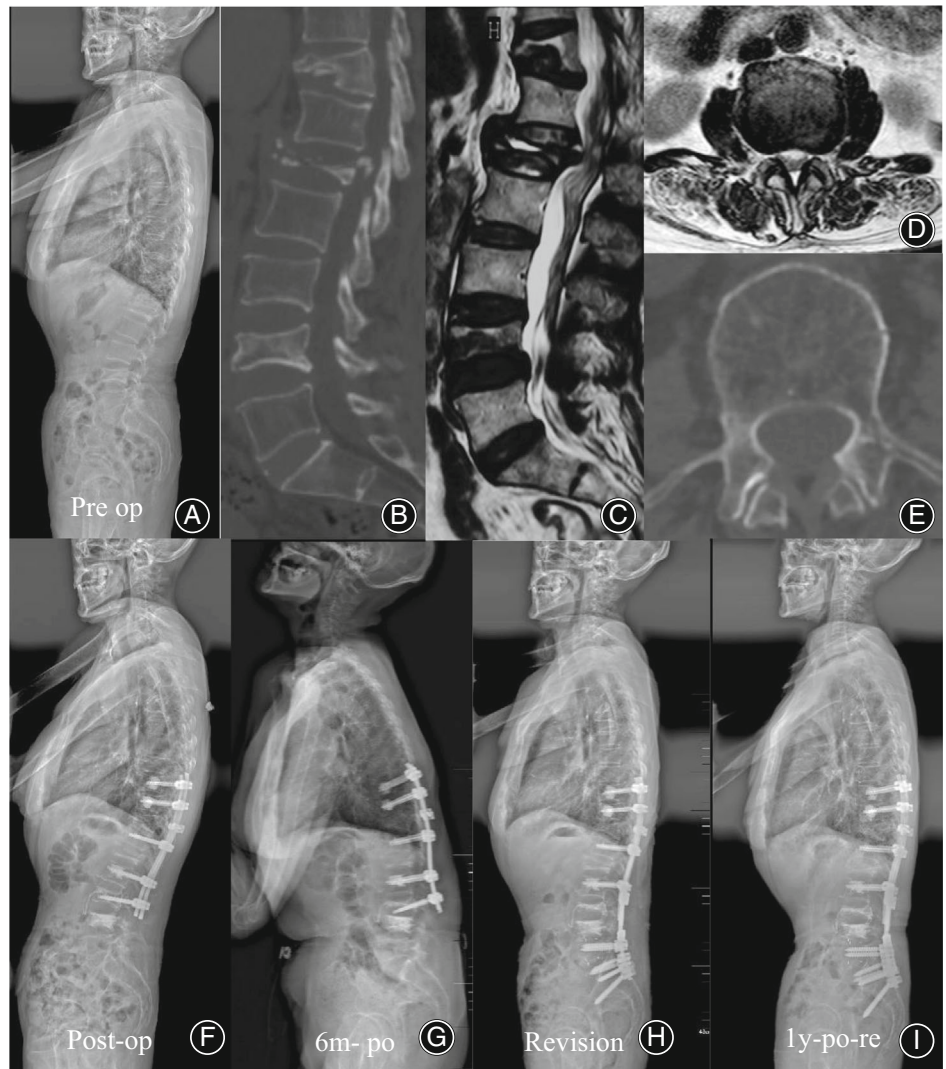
A 64-year-old female patient with posttraumatic kyphosis secondary to old fractures at T11, L1 and L4 (a). She was observed with Kummell diseases at L1 and L4, significant canal encroachment due to unhealed bony fragment at L1(b, c), advanced fatty degeneration of paraspinal muscles (d) and poor bone quality (e; CT attenuation at L3 body: 95.0 HU). Then, she had undergone instrumented fusion from T9 to L3 with cement-augmented screws, Grade IV osteotomy at L1 and vertebralplasty at L4(f). Six months later, unfortunately, she developed distal junctional failure (including L3 fracture and instrumentation failure) and cauda equina syndrome (g). Thus, a decompressive revision surgery was performed with fusion extended to the pelvis (h). The revised correction maintained well at 1 year follow-up (i).
